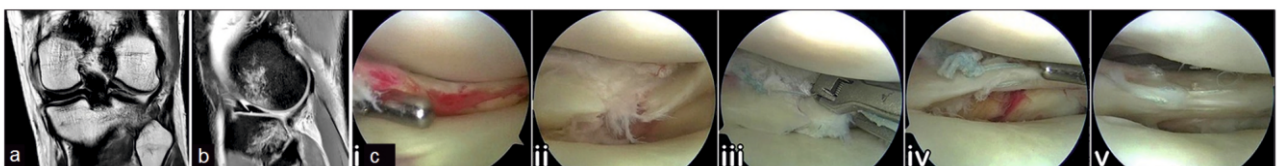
Meniscus repair for complex tear. (a) and (b) MRI reveals a complex displaced transection of lateral meniscus with locked knee.
